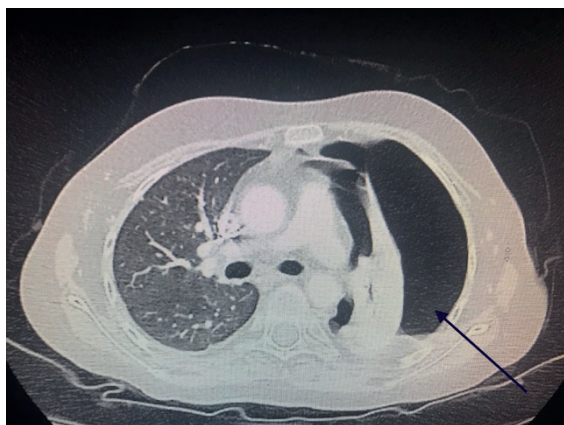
Pulmonary CT scan reveals tension pneumothorax on the left side.
